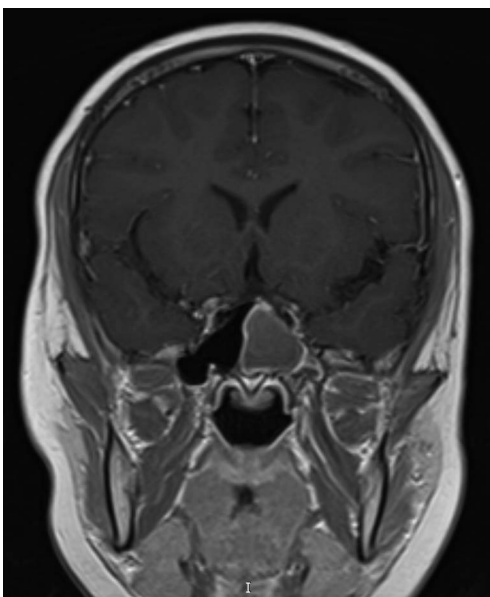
MRI of the head showing left sphenoid sinusitis
